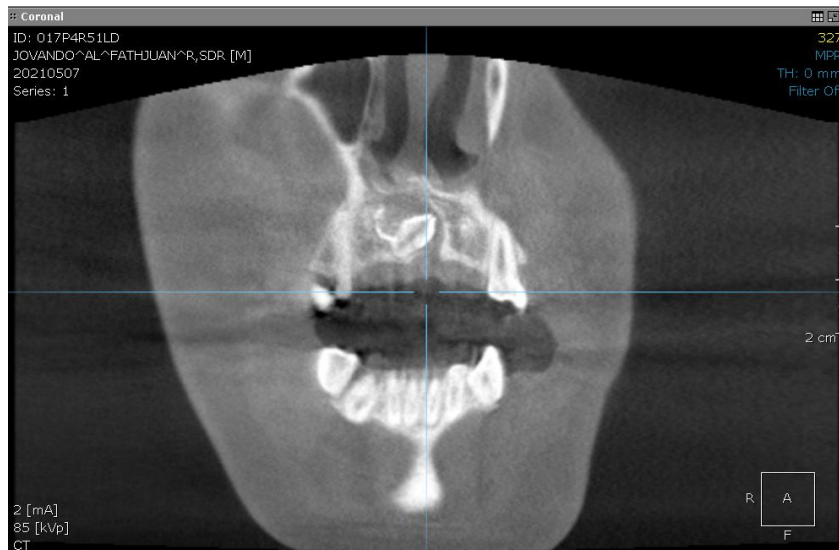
CBCT radiographic view
